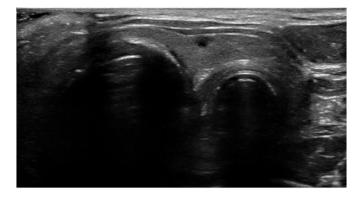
Ultrasound image of an esophageal intubation.
